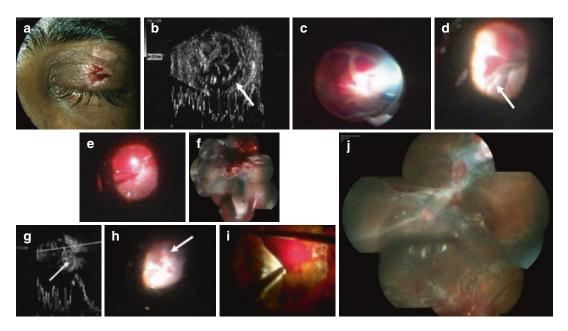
Sequence of events observed in Case 4 of 24year-old male sustaining perforating injury to left eye with sharp metal blade. (a) Repaired lid laceration. (b) Ultrasound showing vitreous hemorrhage and Hemorrhagic CD (arrow). (c) Intraoperative thick vitreous blood and (d) showing mounds of hemorrhagic CD (arrow) with RD noted after clearing the vitreous blood correlating ultrasound scan. (e) Retina attempted to flatten and displace the subretinal blood and choroidal mound to periphery under LPFC. (f) Montage photo of retina under silicone oil after first stage surgery (g) B scan done initially after the globe repair showing superior vitreoretinal incarceration (arrow) correlating with (h) intraoperative findings of retinal incarceration (arrow) after silicone oil removal in second stage surgery. (i) Evacuation of subretinal blood after reflecting the retina. (j) Fundus montage 3 months after second surgery with stable attached retina with extensive scarring tion and globe perforation. On examination, right eye was normal. Left eye had vision of PL and inaccurate PR. There was severe lid edema with lid laceration of 4×2 mm and traumatic ptosis was noted. He also had subconjunctival hemorrhage, the posterior extent of which could not be made out. AC showed hyphaema inferiorly and finger tension was soft. Patient was taken up for lid tear repair and globe exploration. During globe exploration, posterior extension of scleral tear of about 8 mm from the superior rectus muscle was seen and was repaired.
